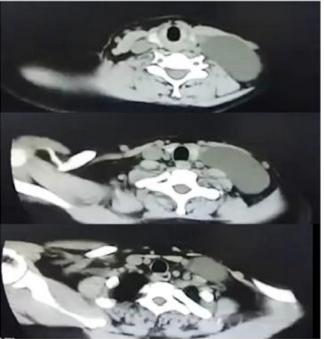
CT showing hypodense lesion in the left side of neck
